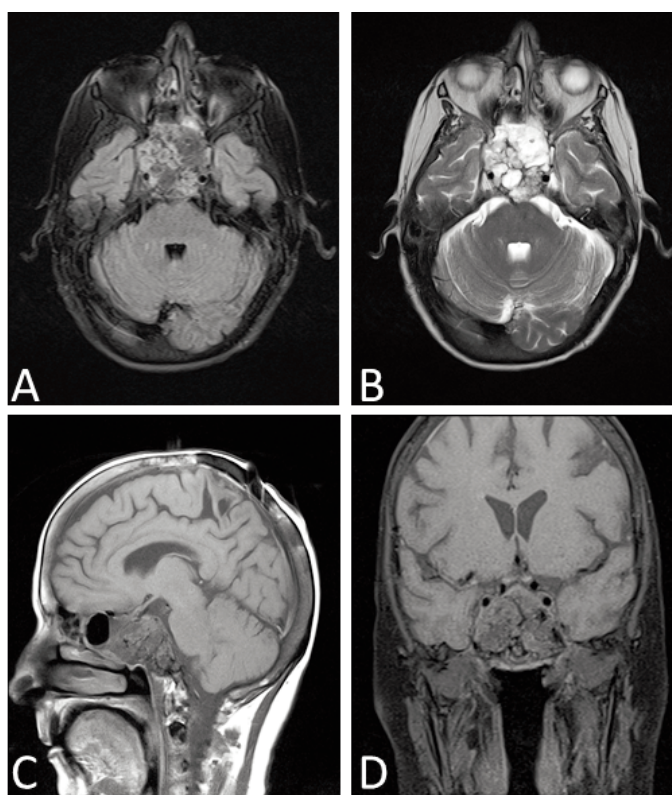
Brain magnetic resonance imaging (MRI) taken on 2015. A) Axial T1-weighted MR image showing an expansile complex cystic/solid mass involving clivus and skull base. B) Axial T2-weighted MR image. C) Sagittal T1 MRI showing involvement of sphenoid sinus and considerable cystic feature of the lesion. D) T1 MRI coronal section.
